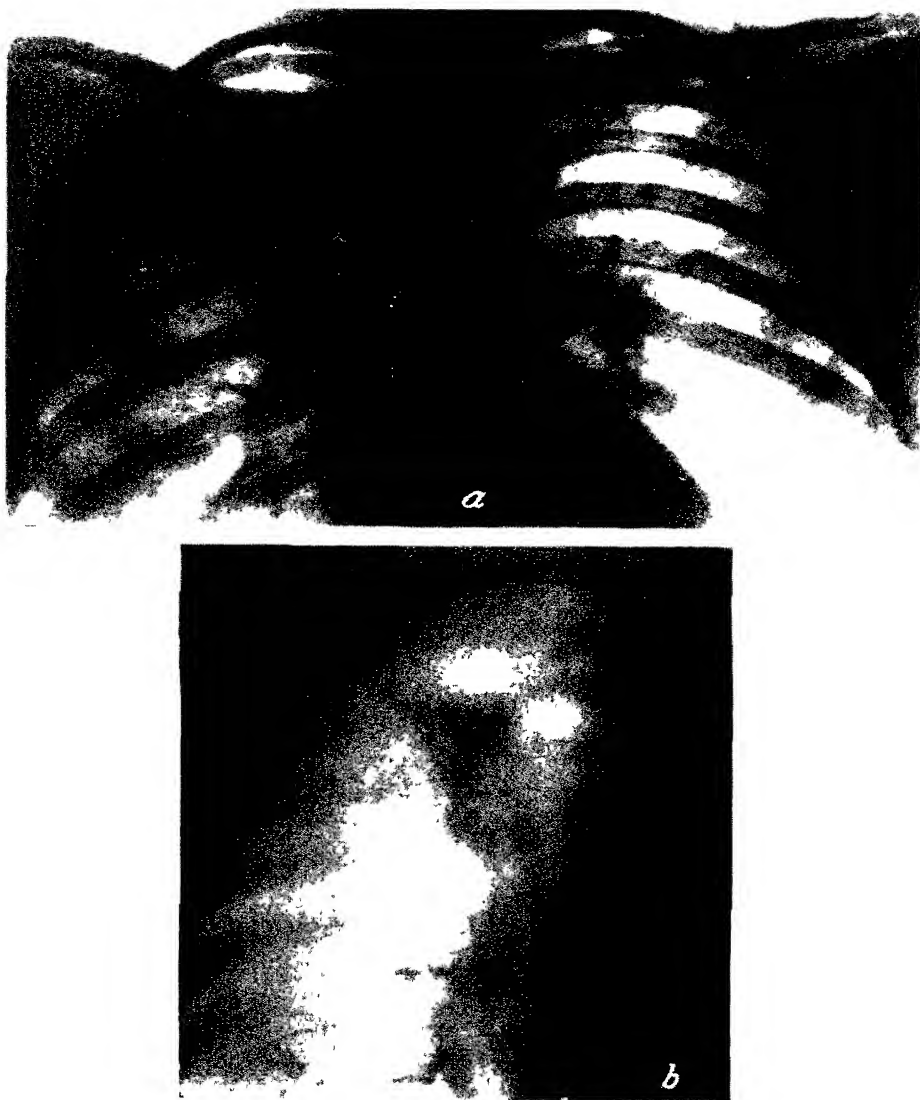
X-rays of patient R Infiltrative pulmonary tuberculosis with disintegration (fresh cavity) on the right
